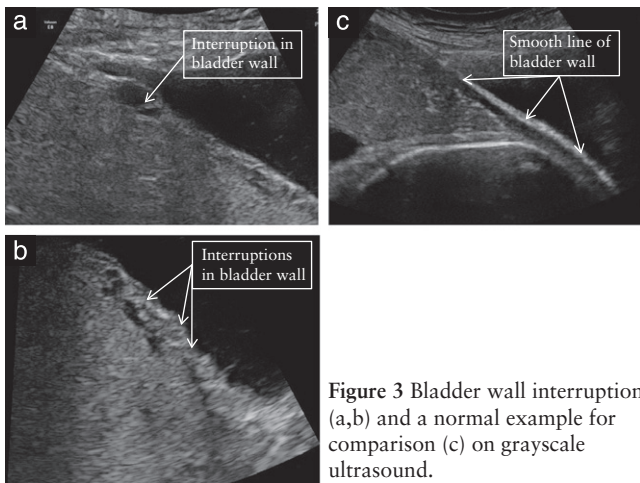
Bladder wall interruption (a,b) and a normal example for comparison (c) on grayscale ultrasound.
